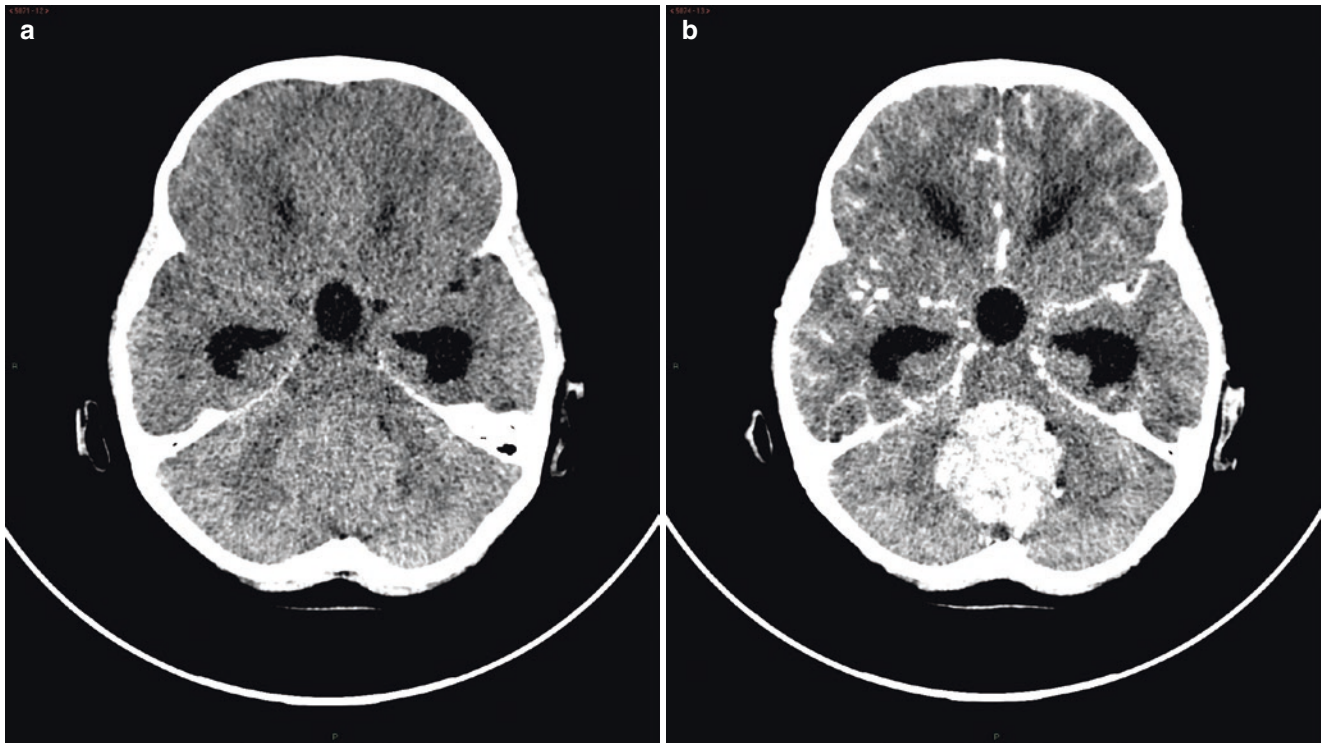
Medulloblastoma. (a) Axial CT image reveals a dense midline mass within the cerebellar vermis, compressing the fourth ventricle and causing hydrocephalus. (b) The mass enhances diffusely following contrast administration
